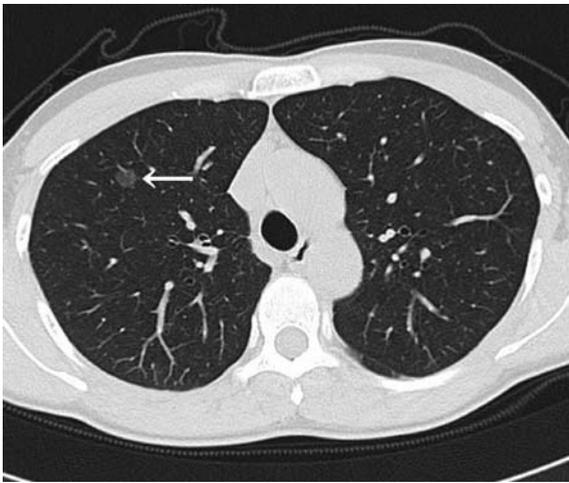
Computed tomographic scan of chest showing a ground-glass opacity 8 mm in diameter (arrow).
